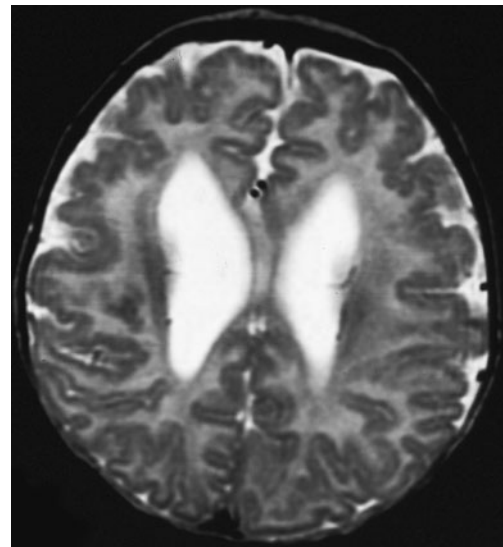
Bilateral frontal polymicrogyria. Axial T2-weighted image shows delicate PMG in both frontal lobes. The lateral ventricles are somewhat dilated
